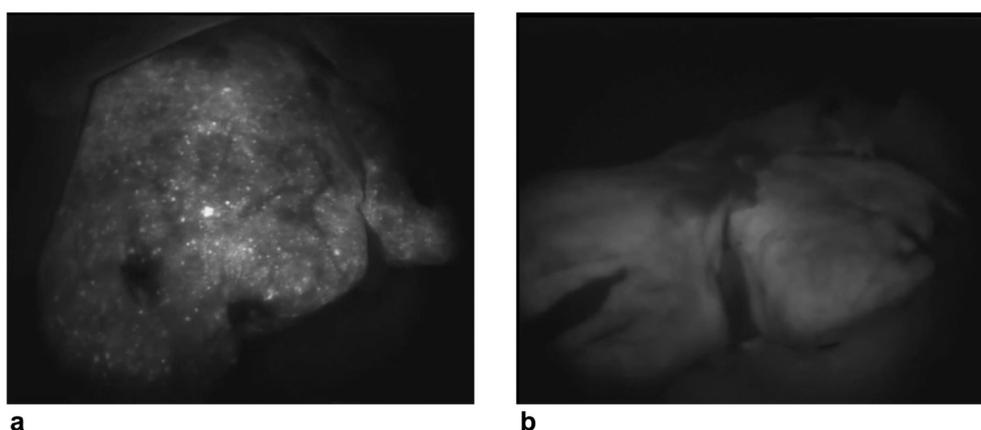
a) Type III fluorescence image of a patient who presented with a PNF. Neither anatomical nor doppler abnormality were detected during LT. The patient underwent re-LT the day after. b) Type I fluorescence image of the same patient after re-LT; postoperative course after the second LT was uneventful. Abbreviations: PNF, Primary Non function; LT, Liver Transplantation
